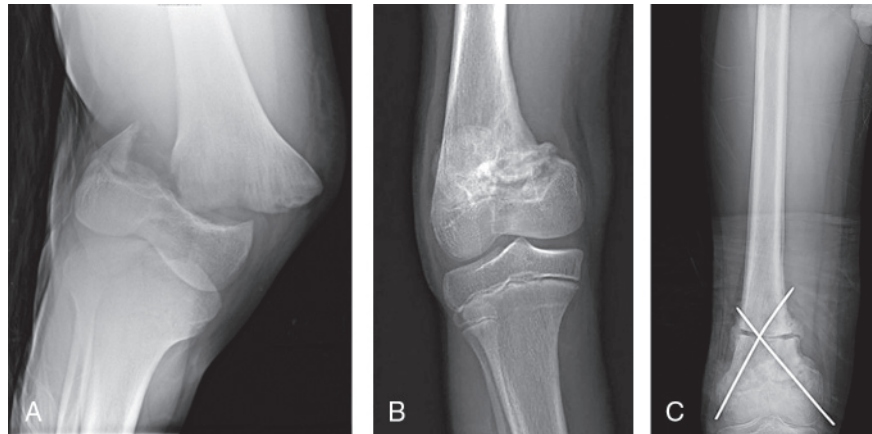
A, AP radiograph taken in the emergency department of a Salter-Harris type II fracture of the distal femur in a 13-year-old boy. B, AP radiograph taken 6 months after treatment shows formation of a physeal bar and angular deformity. C, AP view of the fracture after a corrective osteotomy was performed.
